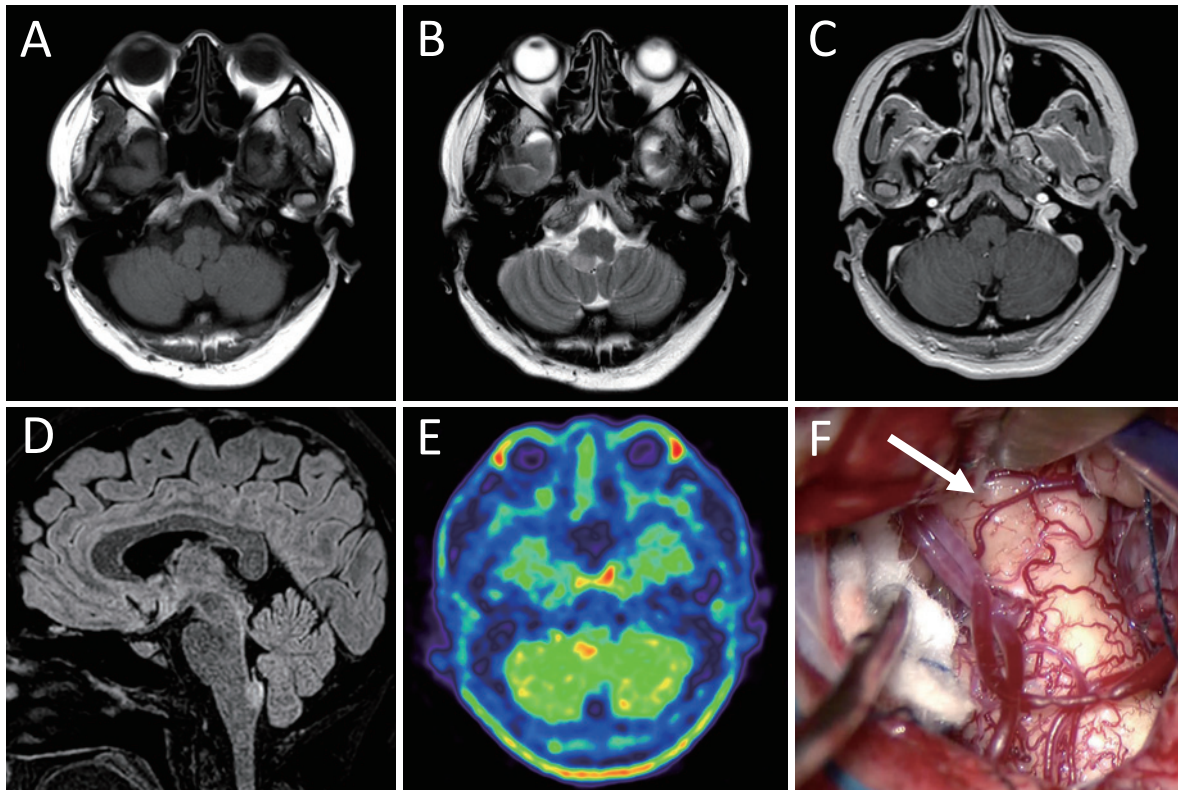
Preoperative axial T1-weighted (A), T2-weighted (B), and T1-weighted imaging with contrast enhancement (C). Sagittal fluid-attenuated inversion recovery imaging (D) and metabolic imaging with ^{11}C -methionine positron emission tomography (E). Intraoperative image (F) demonstrating the protrusion of the dorsal surface of the medulla oblongata (arrow).
